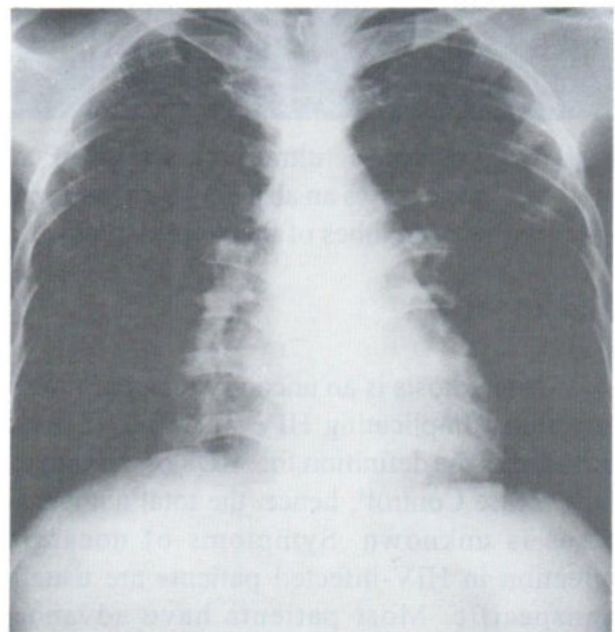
Chest radiograph shows patchy infiltrate with cavities in right middle lobe and reticulonodular infiltrate in both upper lobes.
